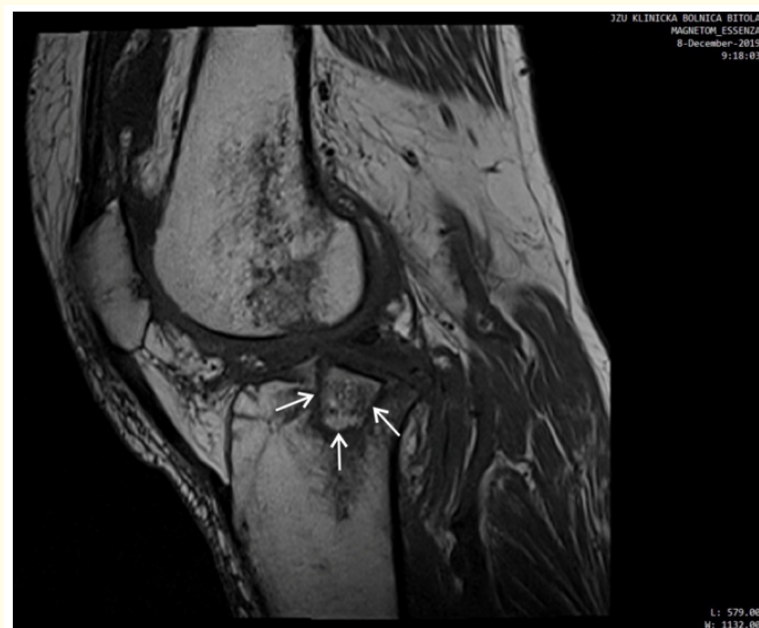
MRI sagittal plane scan of the tibia 19 days after the time of the initial injury.
